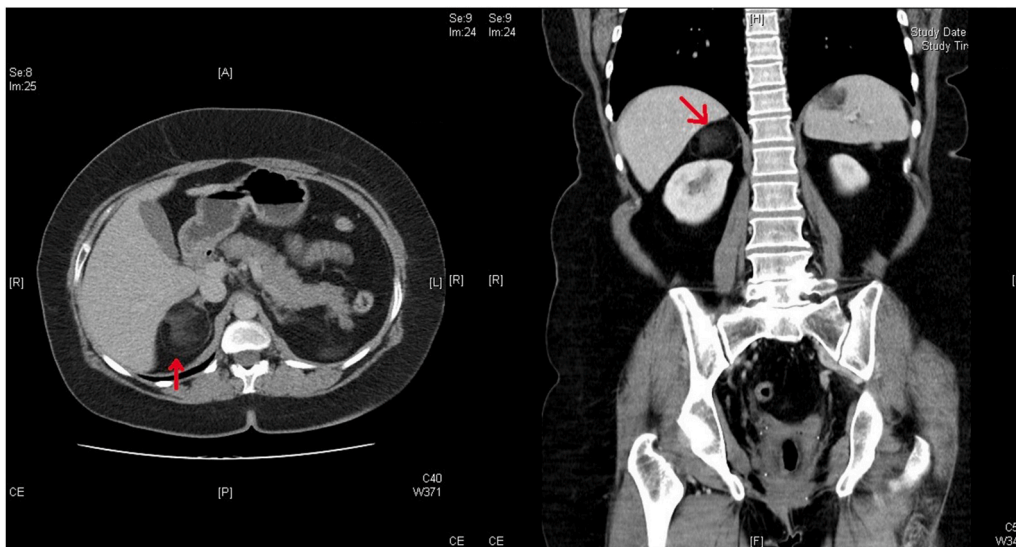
Abdomen CT: A right adrenal gland dependent lesion with areas of fat in its thickness.
